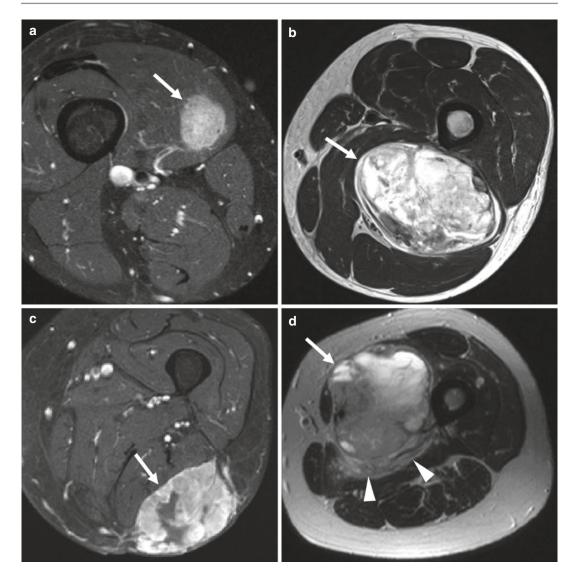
(a–d) T stage according to AJCC/UICC and MSTS. (a) Axial contrast-enhanced T1-weighted TSE image with fat suppression shows intramuscular leiomyosarcoma (*arrow*) in the anterior compartment of the thigh. AJCC/UICC: T1b, MSTS: T1. (b) Axial T2-weighted TSE image demonstrates pleomorphic sarcoma (*arrow*) in the posterior compartment of the thigh. AJCC/UICC: T2b, MSTS: T1. (c) Axial contrast-enhanced T1-weighted
